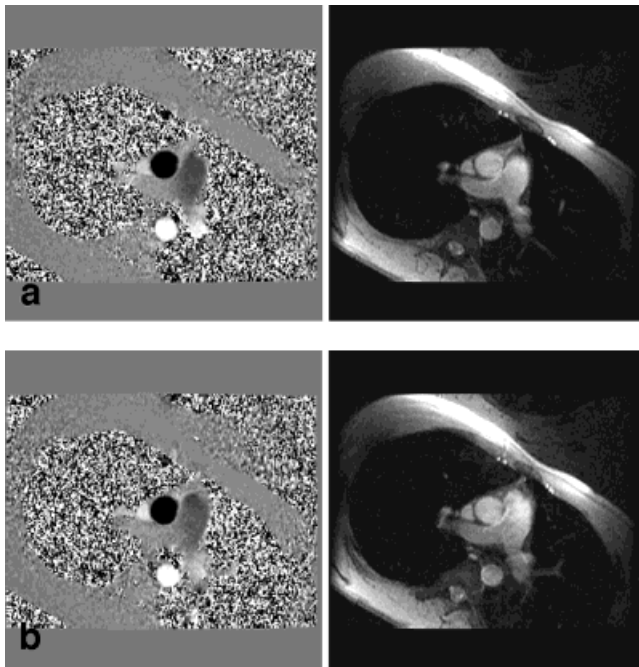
Magnitude (right) and phase-difference (left) velocity-encoded cine MR images of the ascending aorta acquired with small lung volume breath-holding (a) and respiratory triggered acquisition during normal breathing (b). Reconstructed MR images were rotated because of double oblique acquisitions.
